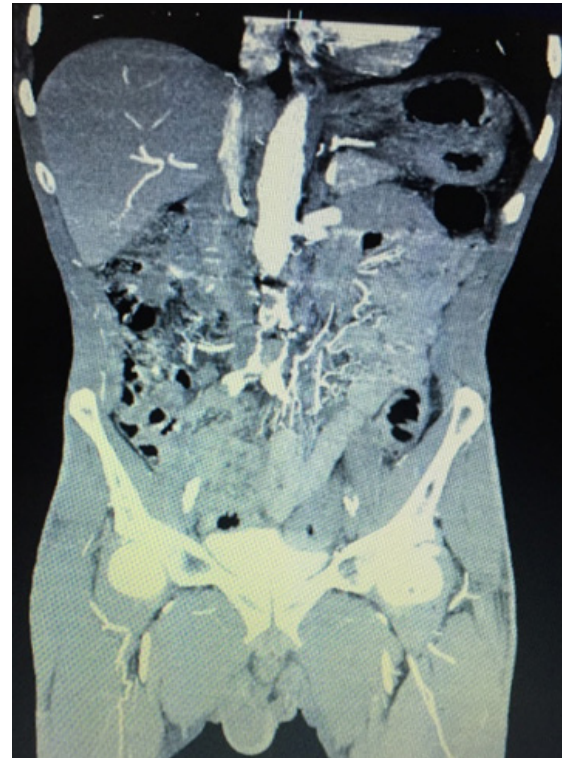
Enhanced computed tomography imaging (axial) demonstrates an acute thrombus in the abdominal aorta causing complete occlusion
